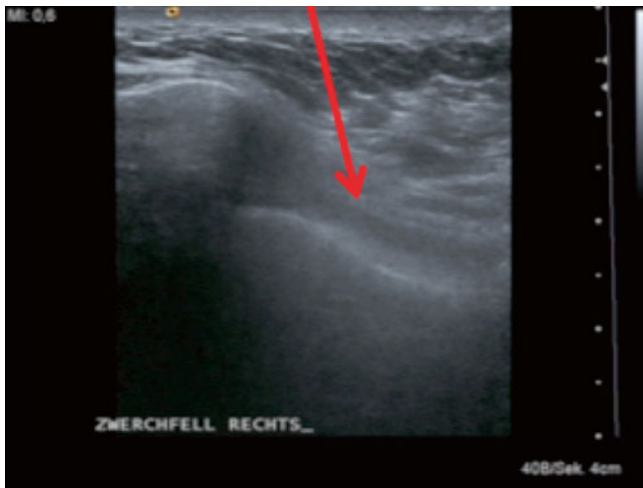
Ultrasound of the diaphragm: ultrasound of the diaphragm, probe between the ribs. *Arrow* points to the diaphragm. Upon inhalation and exhalation, the movement of the diaphragm can be observed
